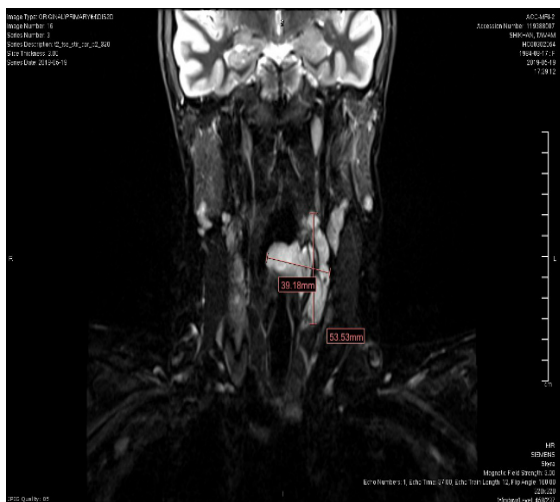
MRI, T2 hyperintense lesion
